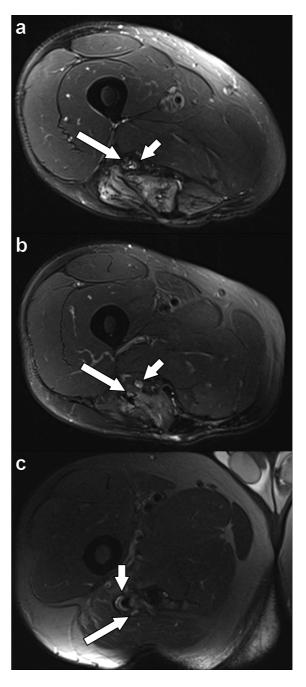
Axial T2-weighted fat suppressed images of the thigh. The peroneal and tibial components of the sciatic nerve are nearly apposed in the distal thigh (A, long arrow, peroneal nerve; short arrow, tibial nerve). The peroneal and tibial components are separated in the upper thigh (B, long arrow, peroneal nerve; short arrow, tibial nerve). There is abnormal posteromedial course of the peroneal nerve more proximally (C, long arrow, peroneal nerve; short arrow, tibial nerve).
